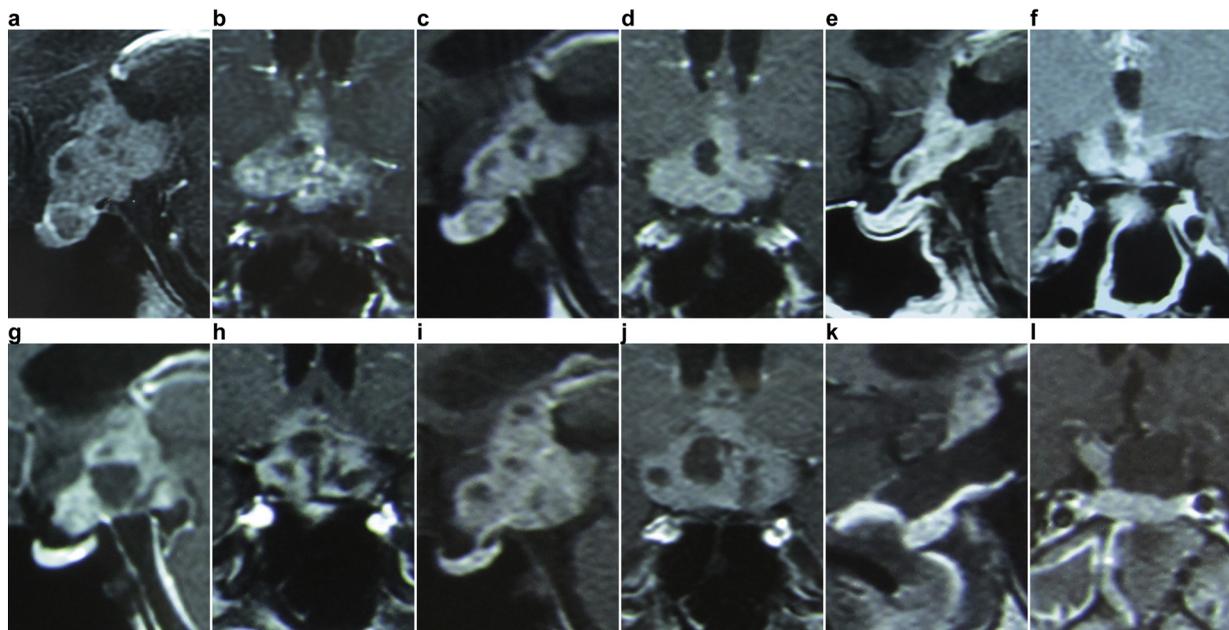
MR images during the clinical course. A and B, Pituitary MRI before the treatment with bromocriptine. C and D, Tumor shrinkage was confirmed on MR images after 1-month treatment with bromocriptine. E and F, Further tumor shrinkage was confirmed on MR images after 3-month treatment with bromocriptine. G and H, Re-growth of tumor despite bromocriptine treatment. I and J, Tumor size rapidly increased in four months later. K and L, MRI demonstrated the residual tumor after endoscopic endonasal approach surgery.
